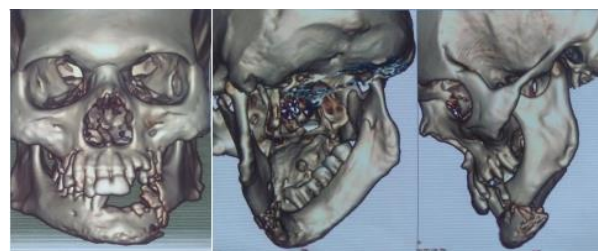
3D CT Scan showing step deformity and osteomyelitic changes.
